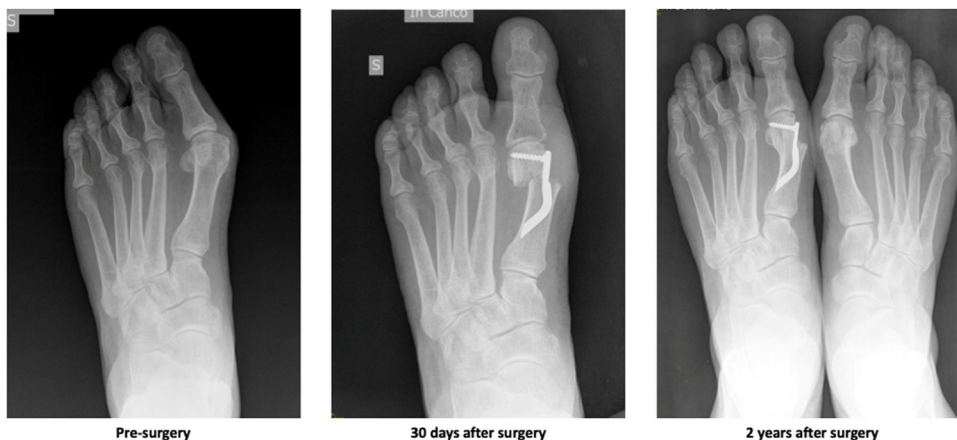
Clinical case of HV correction with Endolog device. Feet X-rays in weight-bearing position were acquired pre-operative, 30 days and 2 years after surgery. The radiological images show a good hallux valgus correction with an excellent healing 2 years after surgery.
